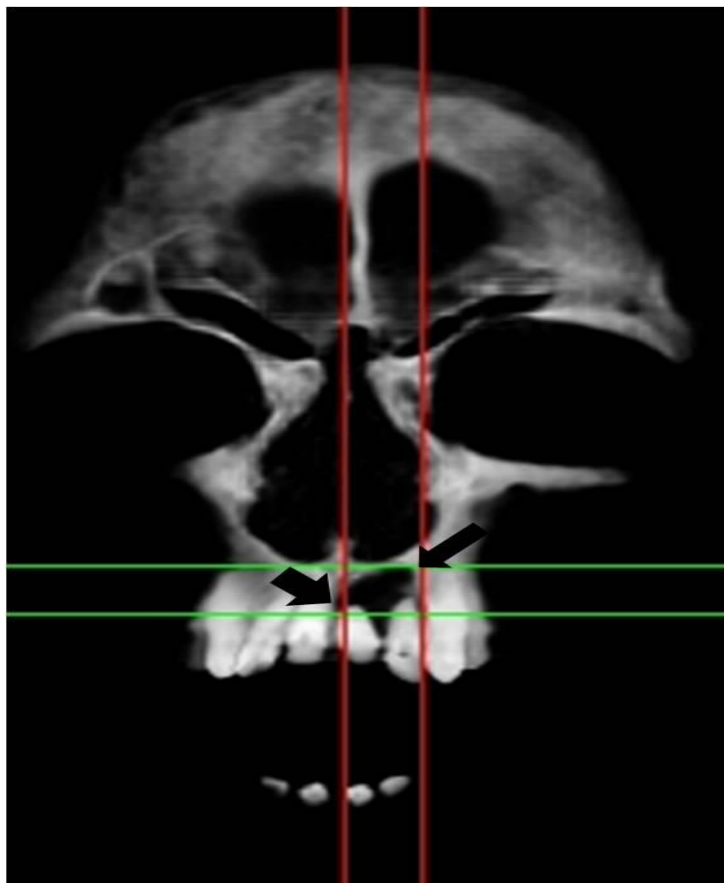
Coronal CBCT image showing cystic lesion
